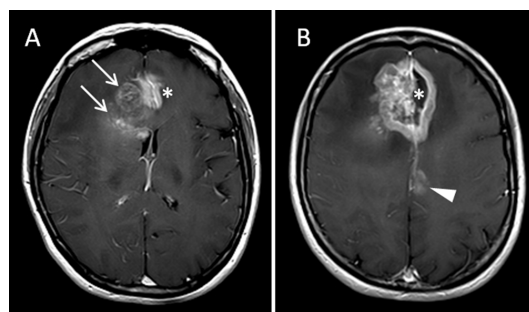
Postgadolinium (Gd) T1-weighted images of two axial contiguous sections showing a highly inhomogeneous lesion constituted of: a right paramedian partially necrotic intra-axial component in genu of corpus callosum and periventricular white matter with infiltrating pattern determining encasement of the right frontal horn (arrows in A); a thick ring-like enhancing midline component with necrotic core, predominantly extra-axial location and infiltration of a thickened falx cerebri (asterisk in A and B). A second intra-axial lesion is seen in left posterior cingulum (arrowhead in B) showing faint irregular enhancement with feathered borders, adjacent to the pathologically Gd-enhancing falx.
